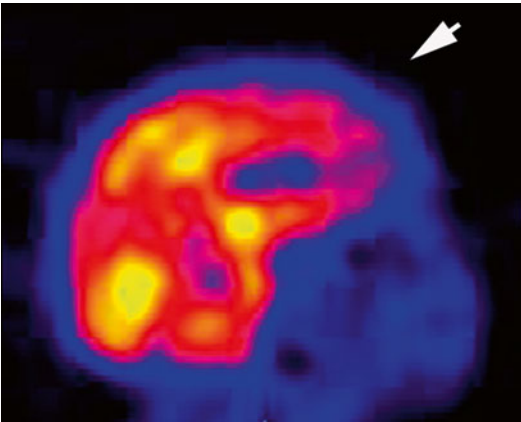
Brain immaturity. ^{99m}Tc-ECD brain SPECT from a newborn showing relatively low cerebral perfusion in the anterior sensorimotor aspect of the brain (*arrow*)
